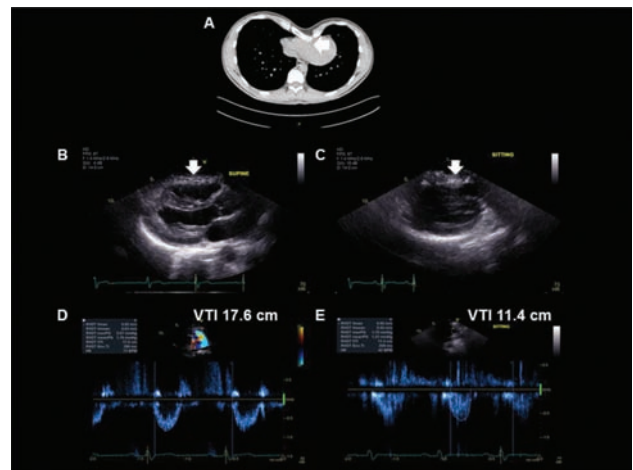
Comparison of Right Sided Hemodynamics based on Position in a Patient with Severe Pectus Excavatum (PE) Deformity. (A) Computed tomography image demonstrating significant PE with significant compression of the right ventricle (RV) [arrow]. (B and C) TTE images demonstrating RV external compression in supine and sitting position (arrow), note the decrease in RV size when the patient sits up. (D, E) Significant decrease in RVOT VTI going from supine to sitting position.
